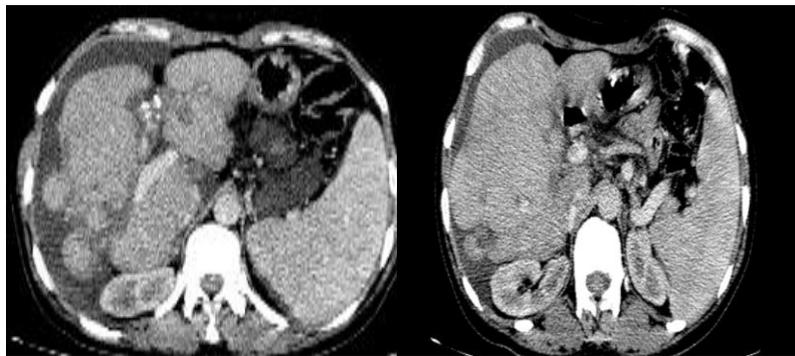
Axial section of an abdominal CT scan with injection showing liver dysmorphism with segment IV atrophy and segment I hypertrophy. Increased caliber TP, permeable
